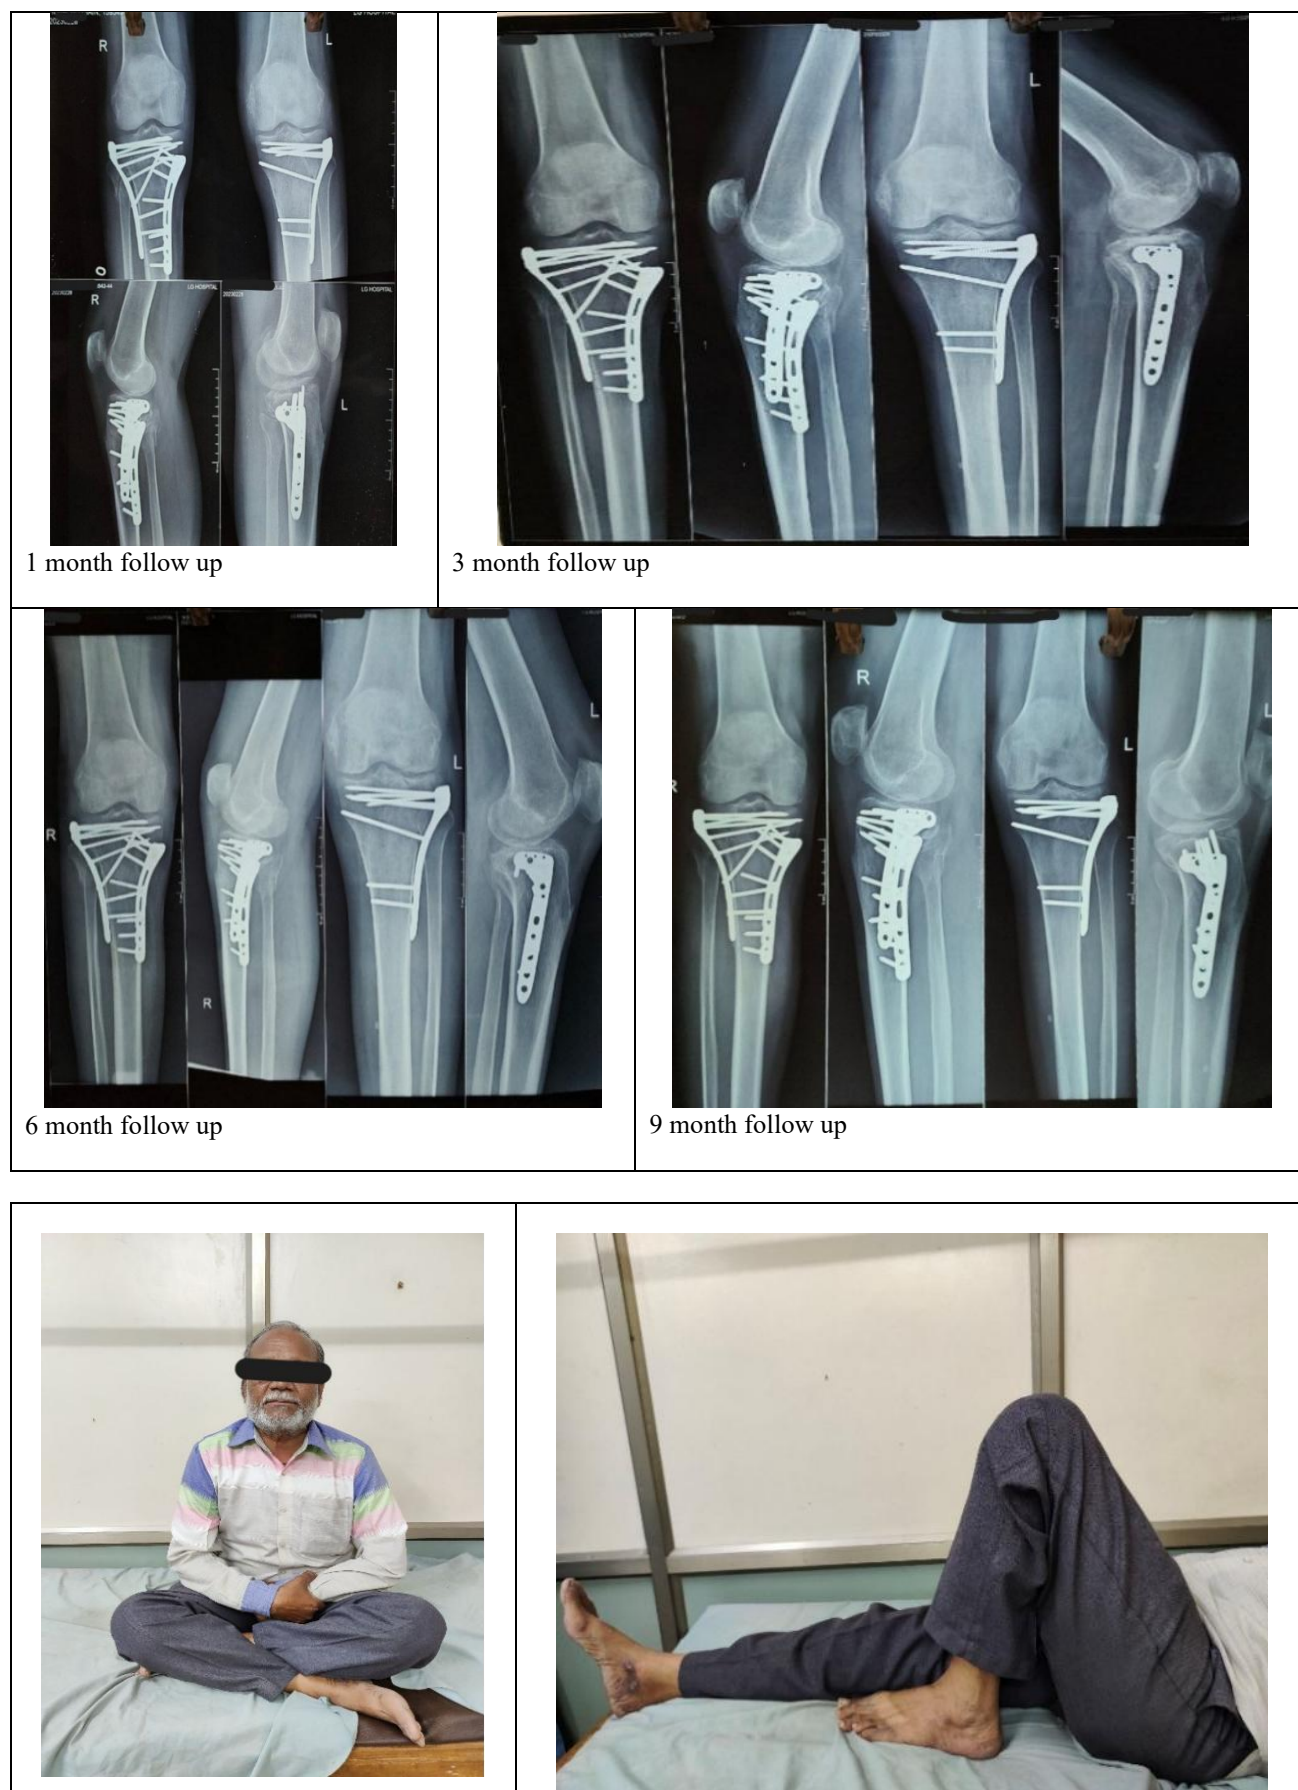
Post-operative radiograph
